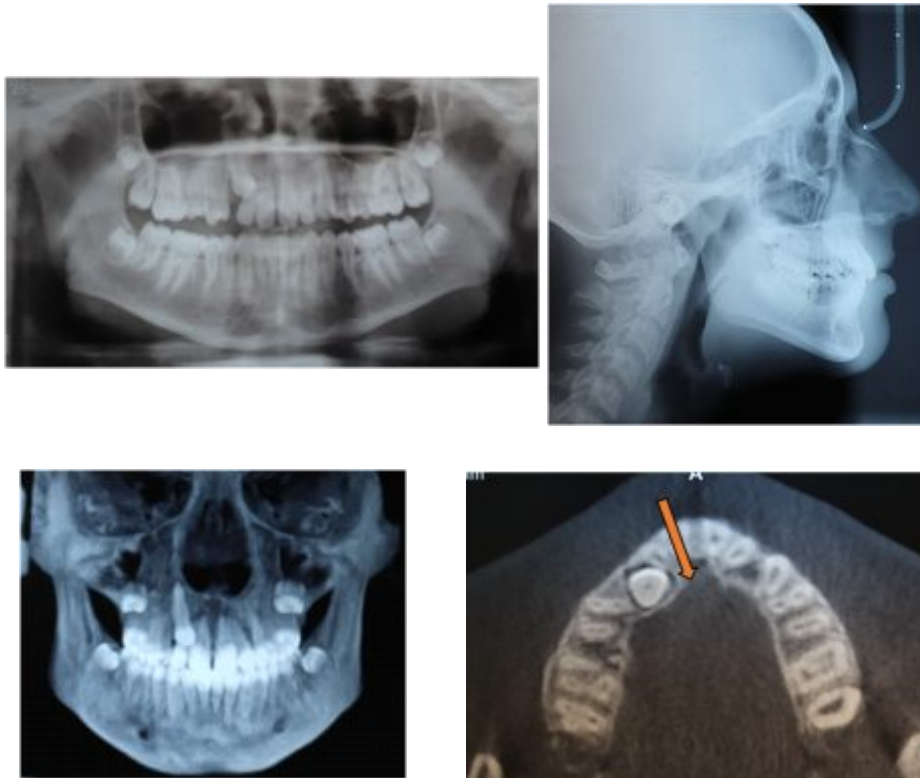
(A-D) Pre-Treatment Radiographic examination
